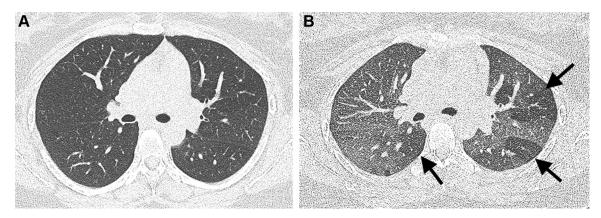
A-B, Inspiratory and expiratory high-resolution (HR) CT images in a 31-y-old woman with asthma. A, Inspiratory HR CT scan demonstrates relatively uniform lung attenuation. B, Expiratory HR CT scan demonstrates mosaic attenuation with geographic regions or darker (air trapped) lung in the left upper and both lower lobes (arrows).
